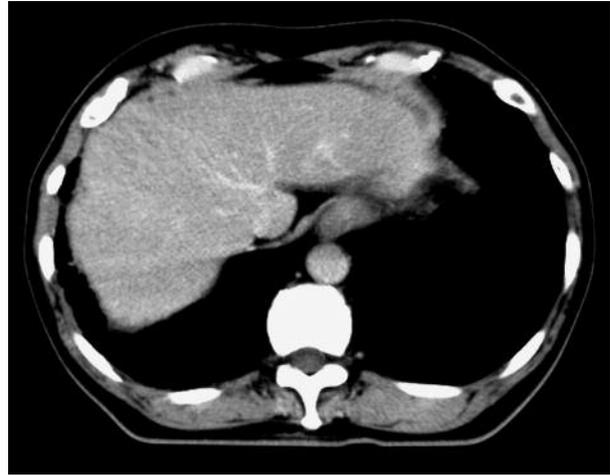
After two courses of chemotherapy, contrast CT showed that most of the low density area had resolved, and the patient was judged to have achieved a partial response.
